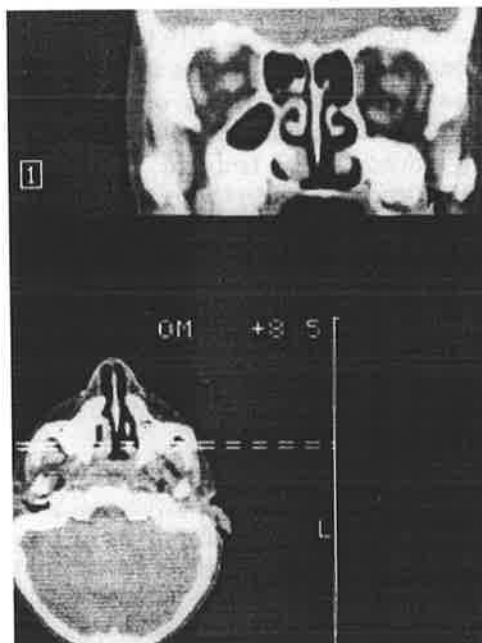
A computed tomogram with two-dimensional reconstruction at right angles to the slice through the marked plane. This view indicates the typical deficiency in the orbital floor and orbital rim, marked by an arrow on the left (the right of the picture)
